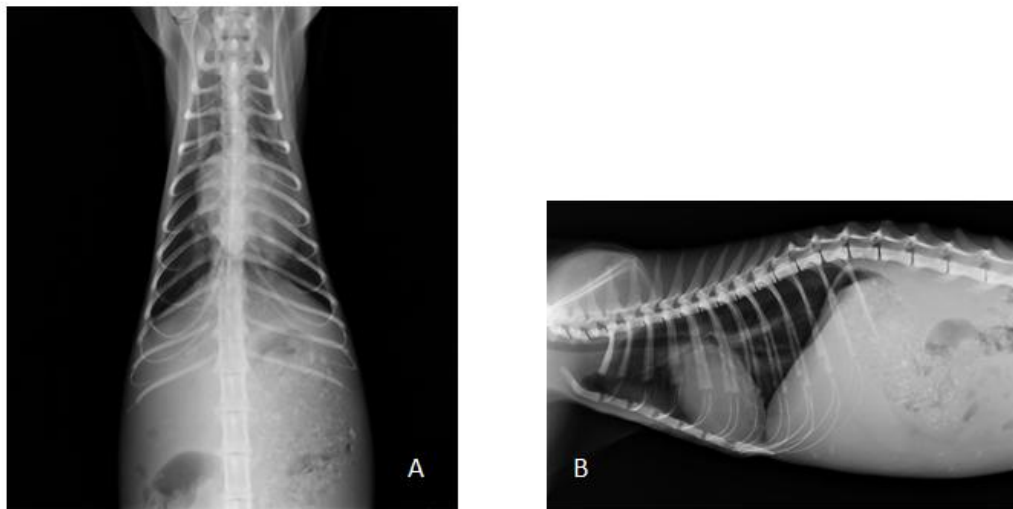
(a) Ventral dorsal view radiography showing cardiomegaly, (b) Lateral view radiography showing pulmonary artery dilatation and pulmonary alveolar pattern.
